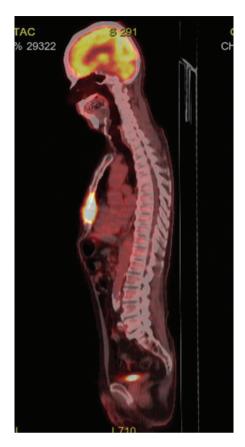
Positron emission tomography-computed tomography showing no uptake other than the sternum.
